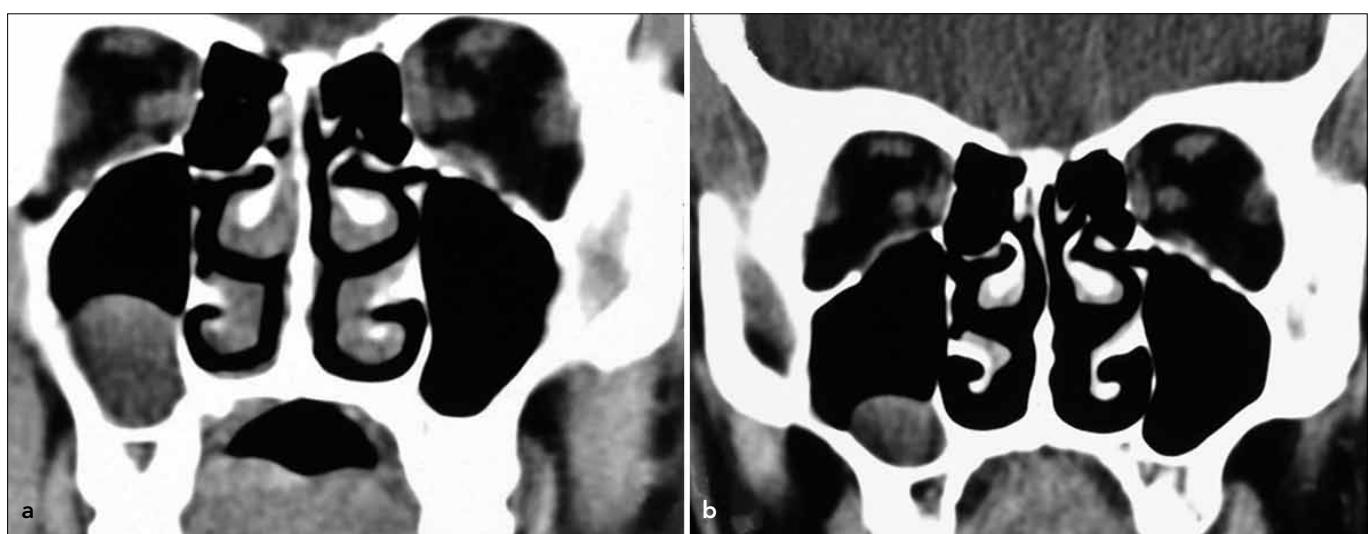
a, b. Coronal CT image (at the soft tissue window) shows a pear-shaped lesion with smooth, well-circumscribed margins, consistent with retention cyst at the right maxillary sinus floor (a). Three years later, follow-up CT image shows that the retention cyst has decreased in size (b).
